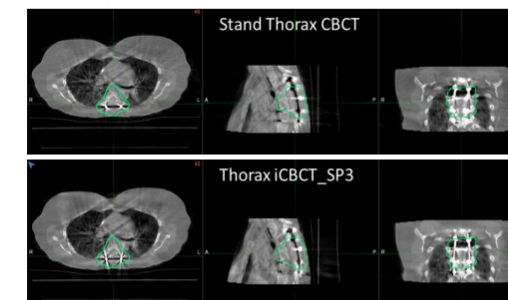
comparison of Standard thorax CBCT to custom Thorax iCBCT protocol
